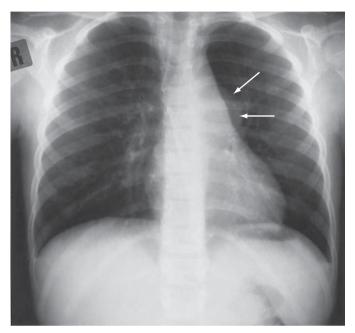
Bronchogenic cyst. The typically rounded hilar mass (*arrows*), seen on this chest radiograph indenting the left main bronchus and lower trachea while deviating the trachea to the right, was confirmed at surgery to be a bronchogenic cyst.
